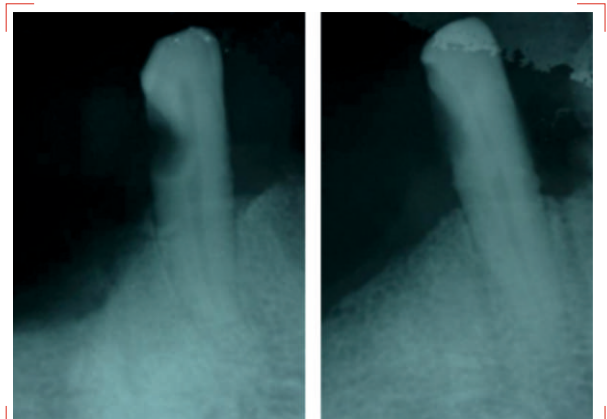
Retro alveolar Radiography which shows a ratio RC/RR ≤ 1 .
